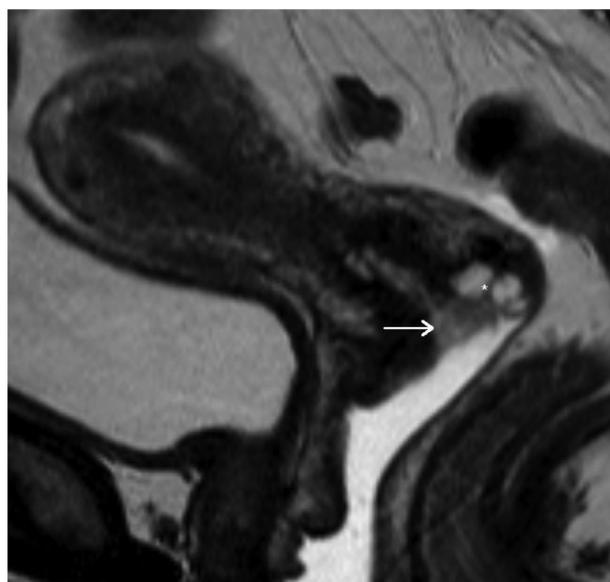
The earliest detectable stage on imaging is Stage IB, which is seen as focal T2 hyperintense signal within the cervix, distinguishable from the normal T2-hypointense signal of the fibromuscular stroma. MRI demonstrates a 1 cm cervical mass (arrow) remote from the internal os. Stage IB1. Nabothian cysts are noted within the cervix (asterisk).
